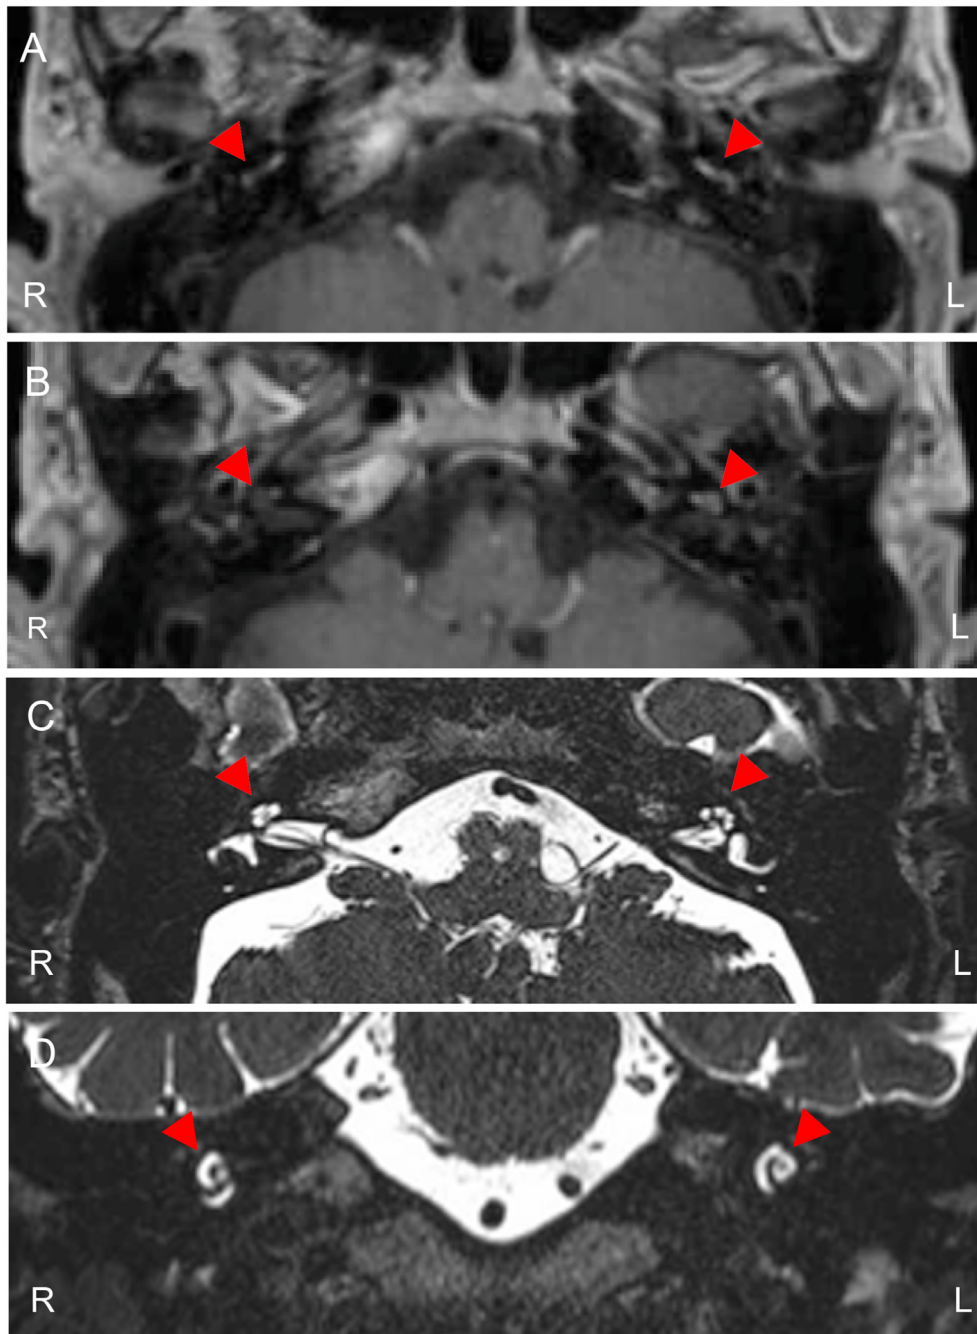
MRI demonstrated the contrast effects in bilateral cochleae. (A) and (B): Horizontal sections of gadolinium enhanced T1-weighted image of cochleae, (C): Horizontal section of T2-weighted image of cochleae. (D): Coronal section of T2-weighted image of cochleae. Arrowheads indicate cochleae.
